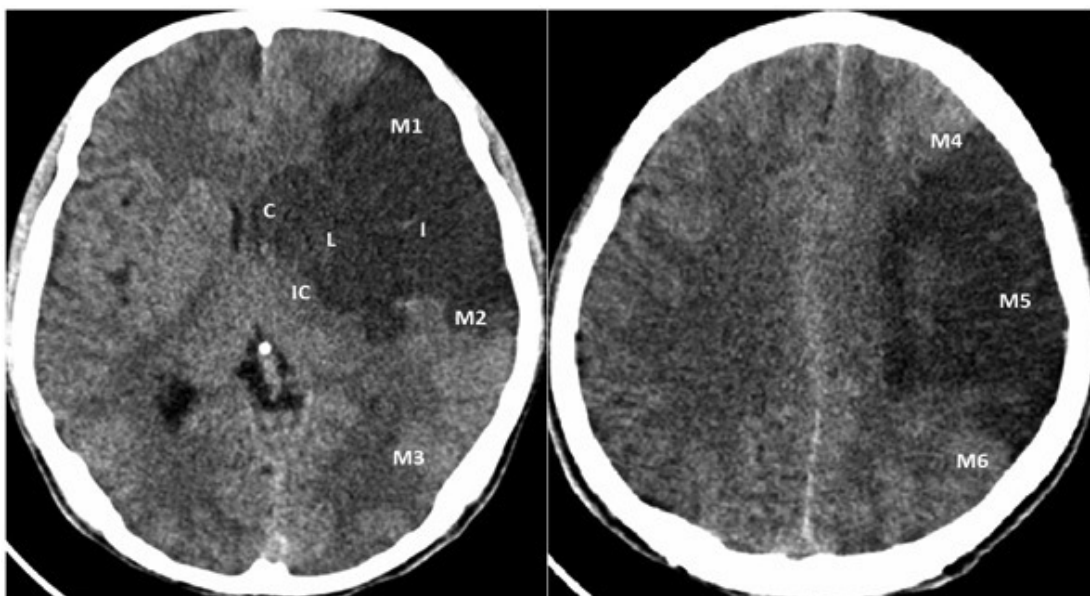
Unenhanced CT brain (Patient no. 18), axial section at level of basal ganglia on left image and at supraganglionic level on right image. There is hypodensity in caudate nucleus, lentiform nucleus, insular cortex, M1, M2, M4, M5 and M6 regions on left side, resulting ASPECTS of 2.
